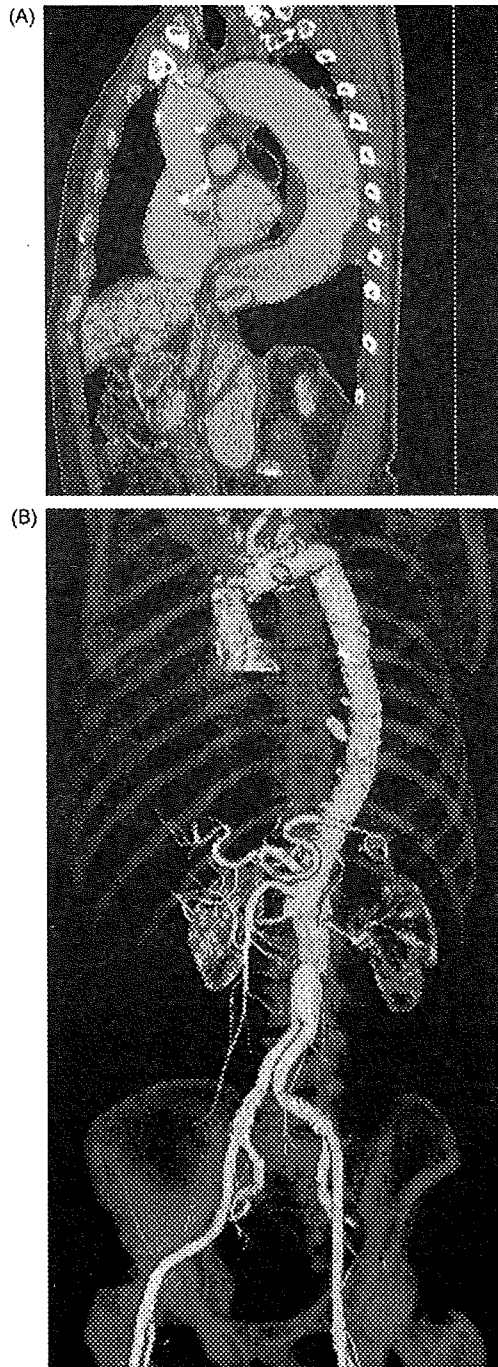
Pre- and postoperative CT scan (case 10). (A) Preoperative CT scan demonstrated chronic type A dissection from the arch to thoracoabdominal aorta after hemi-arch replacement. (B) Postoperative CT scan showed entire thoracic and thoracoabdominal aortic aneurysm replacement.
